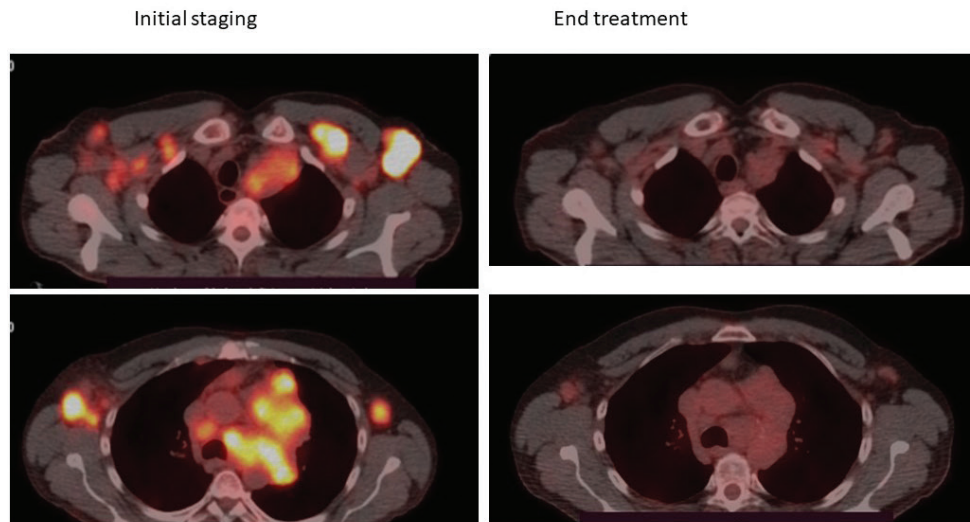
Initial evaluation-Lymph node blocks and pathologic enlarged lymph nodes were detected lateral to aortic arch (size 8X6cm) (SUVmax=11), left pulmonary hilum, pretracheal, aortopulmonary window (diameter 5,6cm) (SUVmax=16,6), supraclavicular bilateral (diameter 3,4cm) (SUVmax=11,2), subclavicular bilateral (diameter 5cm), upper left paratracheal (SUVmax=14,7), axillary bilateral (diameter 4,3cm)(SUVmax=17,4). End treatment evaluation- Lymph node blocks and pathologic enlarged lymph nodes were detected with decreased size and uptake.
